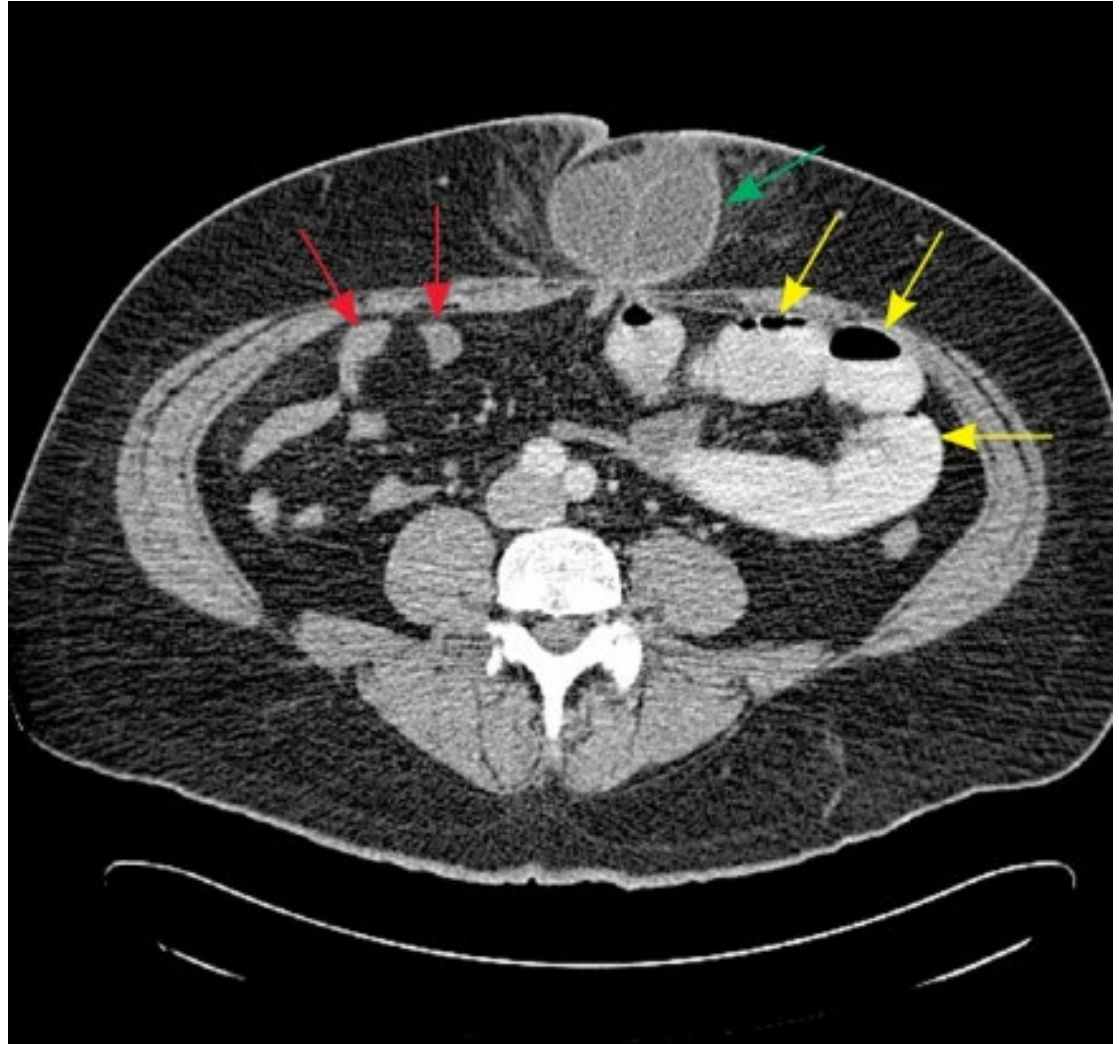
Image retrieved from: <https://healthjade.com/wp-content/uploads/2018/01/CT-scan-bowel-obstruction.jpg>
